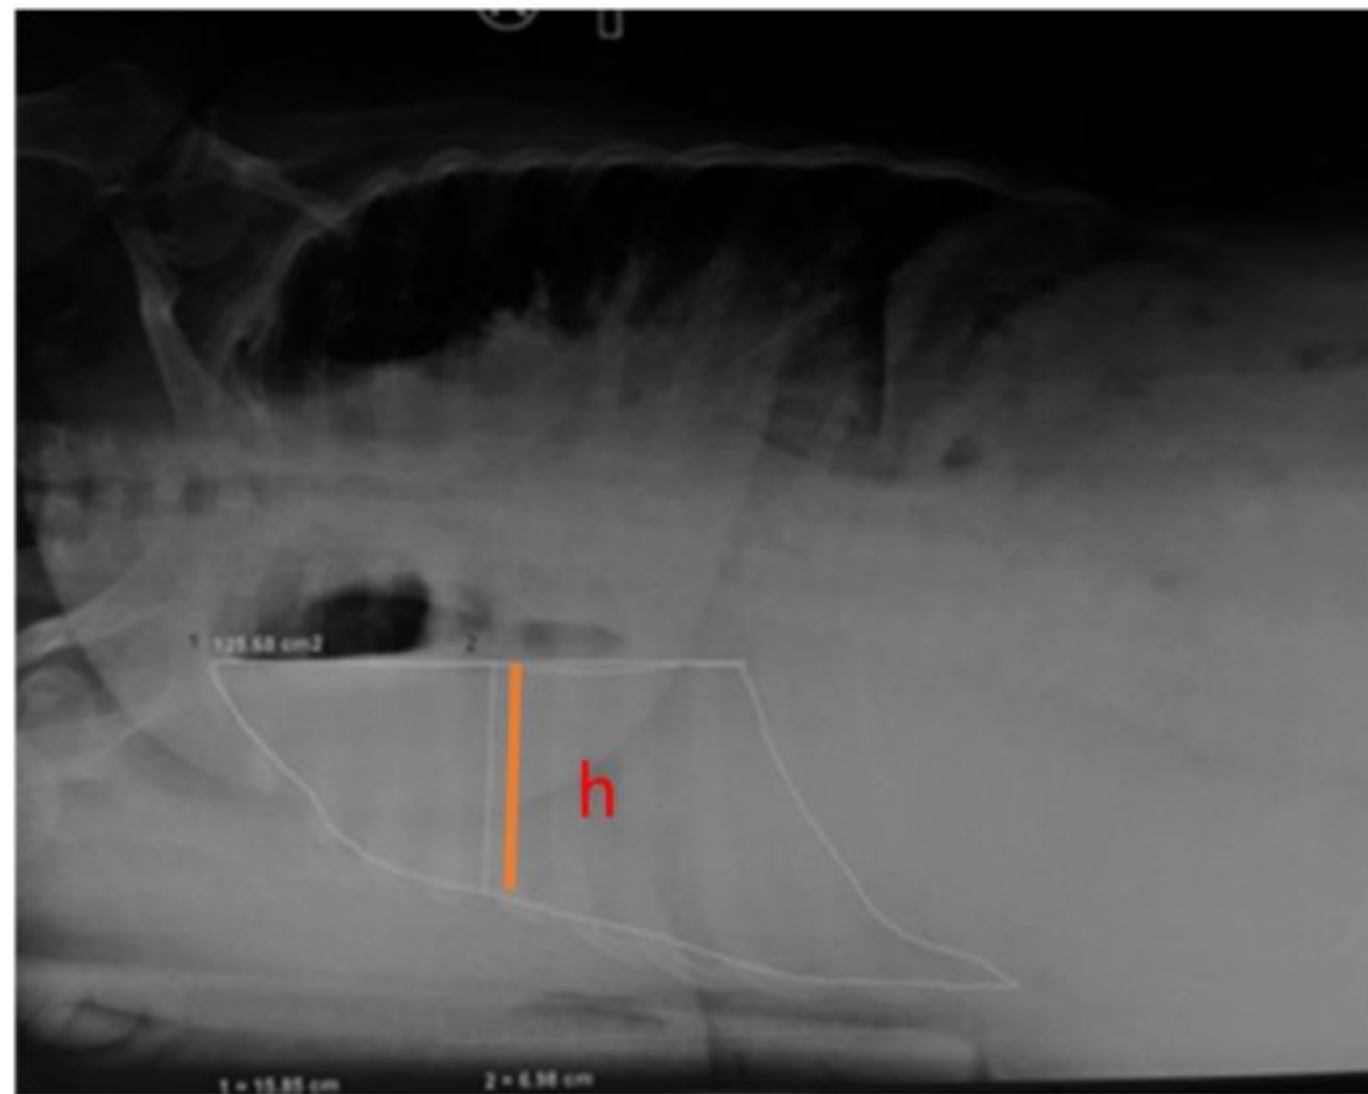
Height measurement of image of pleural effusion (h) of lateral decubitus position of chest x-ray.
